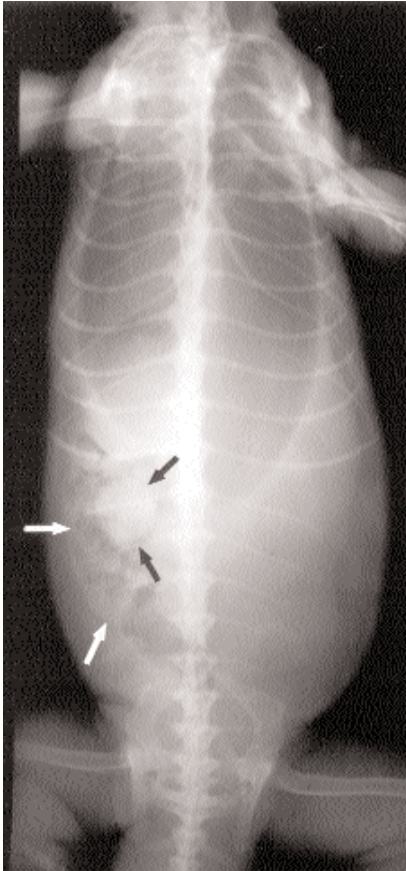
The same radiograph as in Figure 2. Note the mottled gas and soft tissue density pattern (white arrows) and the circular soft tissue density (black arrows) on the right side of the coelomic cavity.
